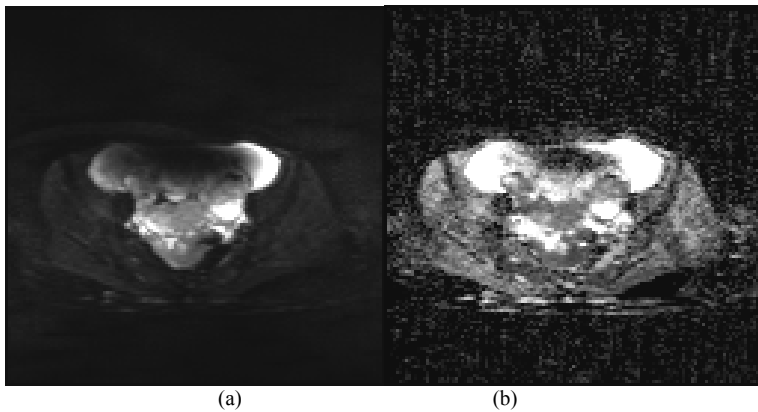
In DWI (a) and ADC (b) sequences, the solid tumor showed areas of restriction.
